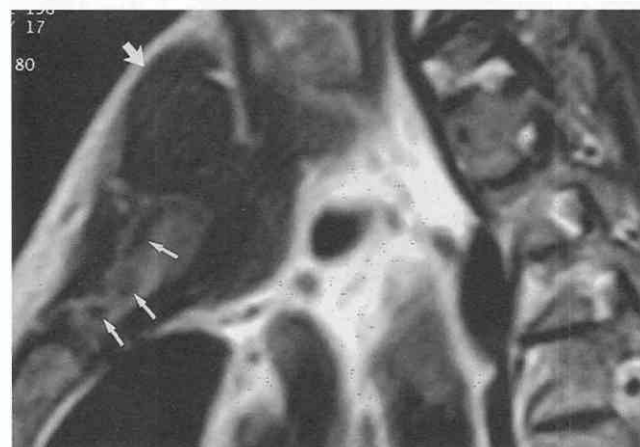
Sternoclavicular joint infection and osteomyelitis in a 48-year-old man with an infected subclavian venous catheter. Sagittal T1-weighted (TR = 400 msec, TE = 12 msec) image shows abnormal areas of low signal intensity (arrows) in the sternal marrow, consistent with osteomyelitis. Surrounding low signal intensity (arrow) in the soft tissues is consistent with abscess. (From Knisely BL, Broderick LS, Kuhlman JE: MR imaging of the pleura and chest wall. *MRI Clin North Am* 8: 125, 2000.)
